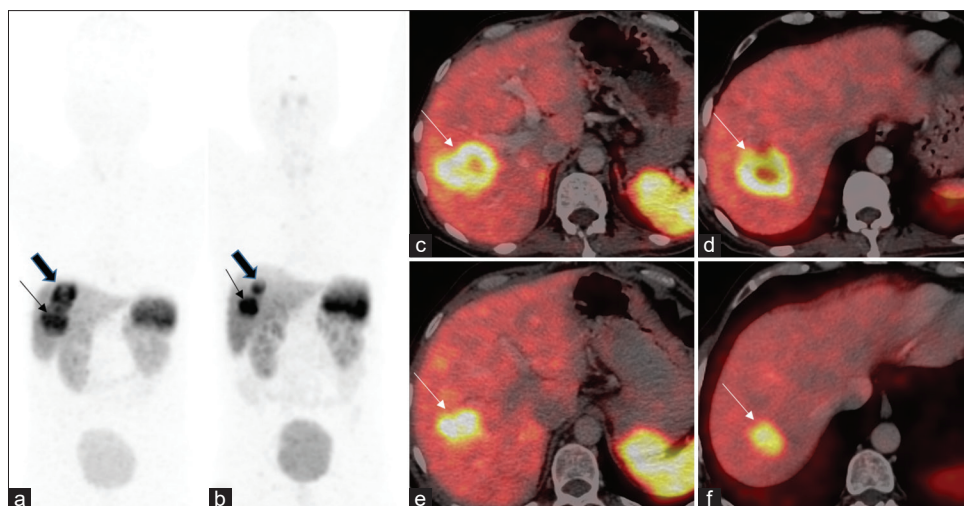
A 54-year-old male presented with two large discrete liver lesions, biopsy was suggestive of WHO Grade 1 NET. Baseline Ga-68 DOTATATE PET/CT showed two tracer avid lesions in segments VII (a: block arrow) and V (a: arrow) on MIP image, which was confirmed on axial PET/CT images (c and d: arrows). Patient was treated with 1 cycle of IA PRRT, and at 8 weeks, Ga-68 DOTATATE PET/CT was done for assessing response. MIP image (b: block arrow and arrow) shows reduction in extent and intensity of uptake in both lesions, which corresponded to reduction in size and metabolic activity of liver lesions (e and f). PET/CT: Positron emission tomography/computed tomography, IA PRRT: Intra-arterial peptide receptor radionuclide therapy, NET: Neuroendocrine tumor
